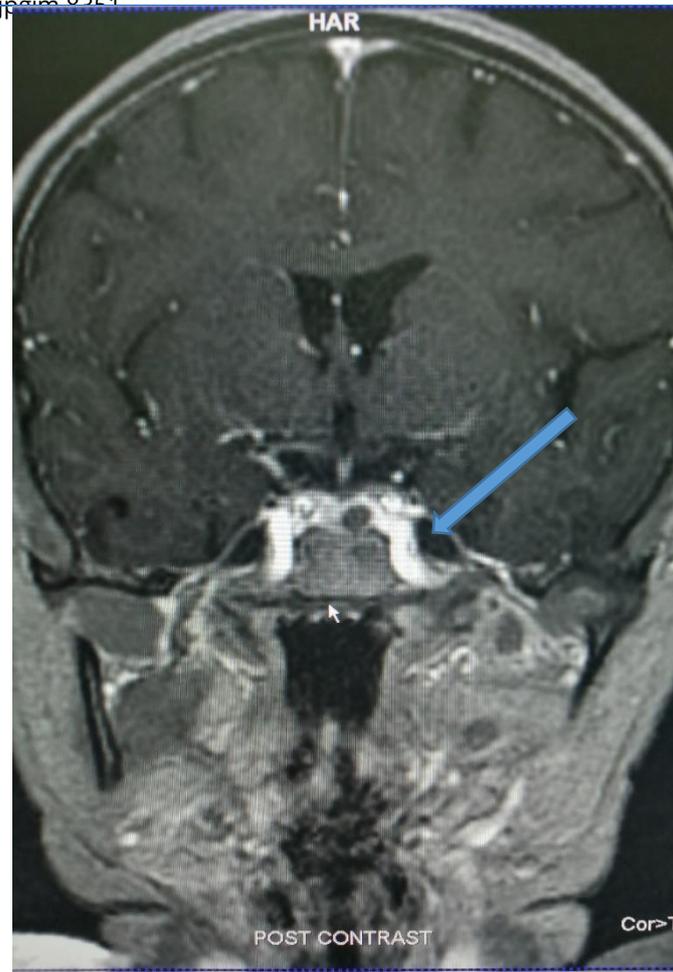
MRI scan of pituitary revealed a mass of 5×5mm in size with delayed contrast enhancement
